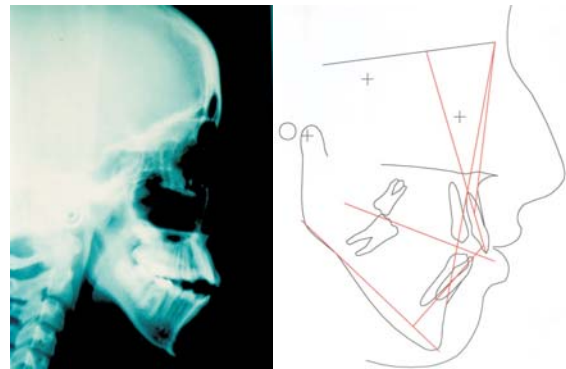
Initial cephalometric radiograph, tracing and measurements of Case A.
